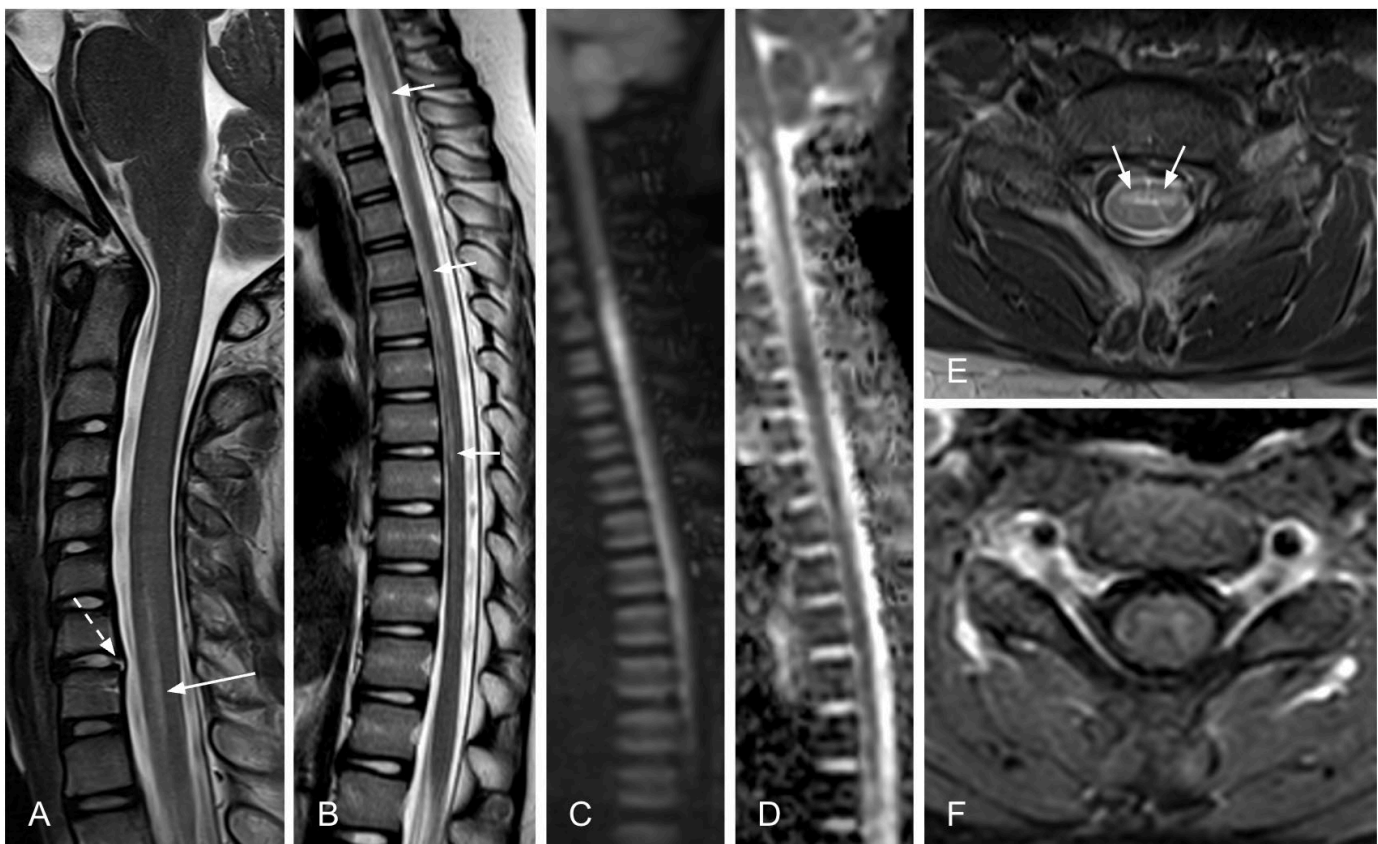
MRI on admission. A. Sagittal T2 of the cervical spine shows longitudinal hypersignal in the ventral cord beginning at C5 (solid arrow). A central annular fissure with small disc protrusion at C6-7 is also present (dashed arrow). B. Sagittal T2 of the thoracic spine shows extension of longitudinal hypersignal to T8. C/D. DWI/ADC images show associated diffusion restriction. E. Axial T2 at C6-7 shows hypersignal in the ventral horns (“owl’s eye” sign). F. Axial postcontrast shows questionable faint associated enhancement.
